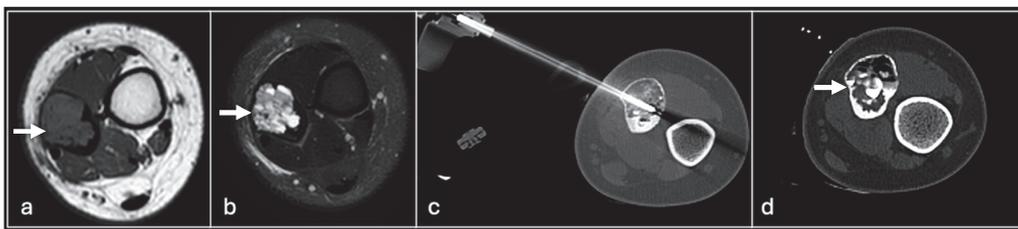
Axial T1 (a), STIR (b) showing aneurysmal bone cyst of fibula (arrow) treated with sclerotherapy under CT guidance (c,d).
